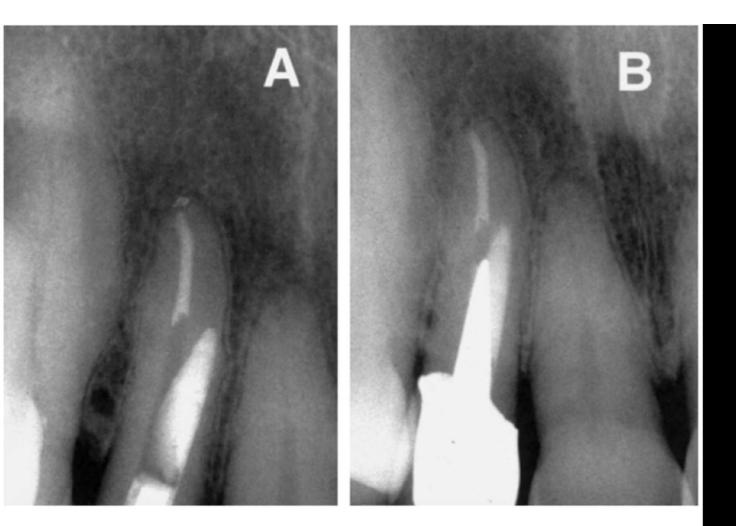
Radiographs of the maxillary right lateral incisor with a lateral perforation. *A*, Postoperative radiograph taken immediately after the repair of the perforation. *B*, Radiograph taken 18 months after perforation repair.
